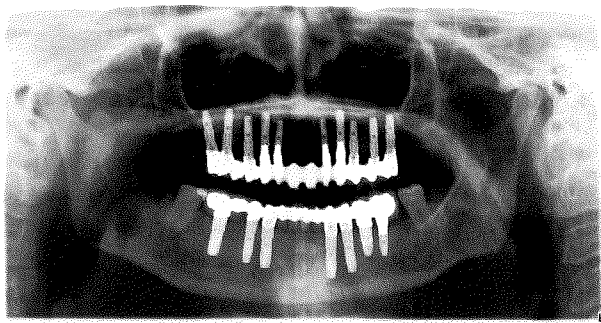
Radiograph after 1 year.*
